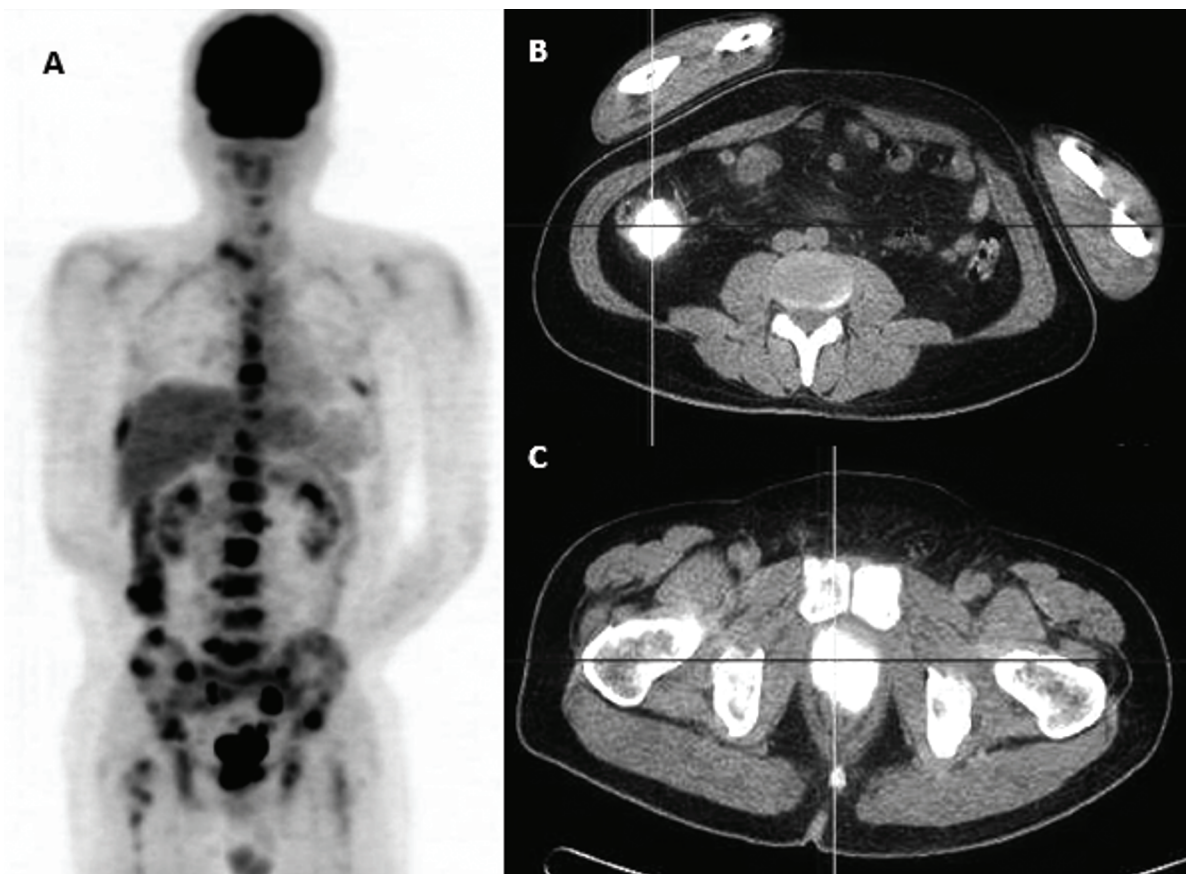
Whole body PET/CT scan showed intense ^{18}F -FDG uptake in the entire skeleton, including cervical, thoracic, lumbar spines, sacrum, rib cages, pelvis, and right femur (A); Unusually high FDG uptake was found in the right abdomen with several focal intense FDG activity localized in the right ascending colon (B) and prostate region (C)
